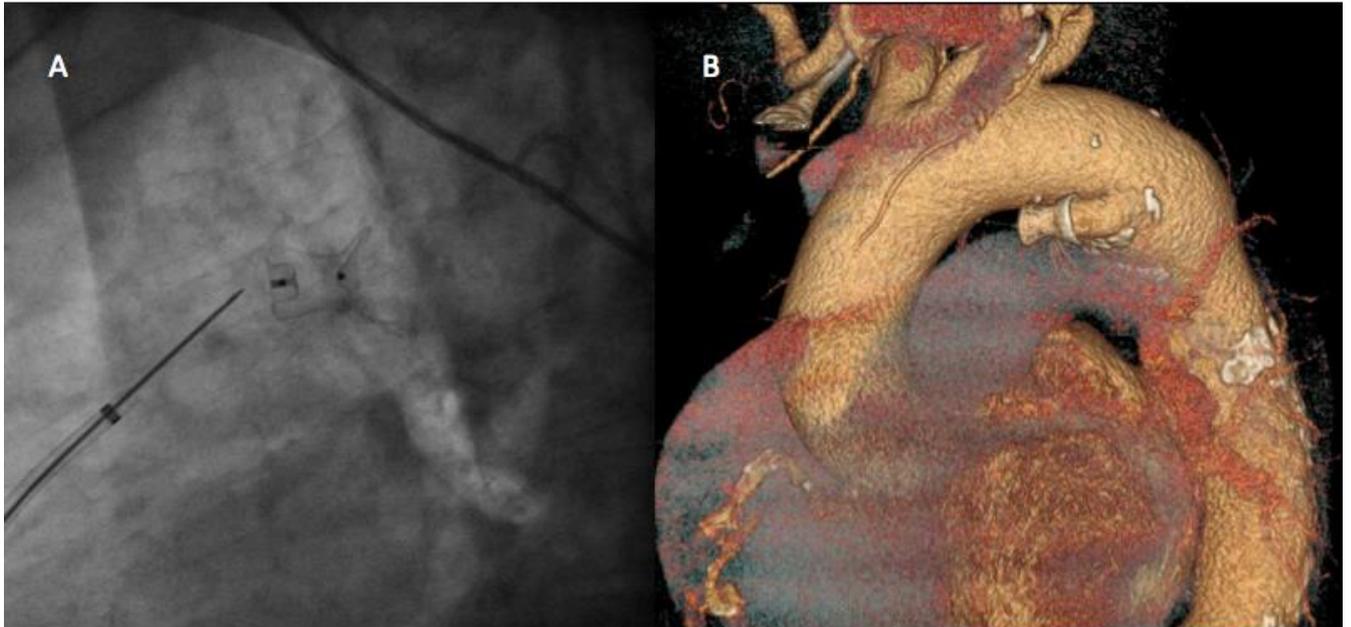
A) Final angiography showing the closure device placed successfully in PDA. B) Cardiac CT six months later, with a right position of the device.
